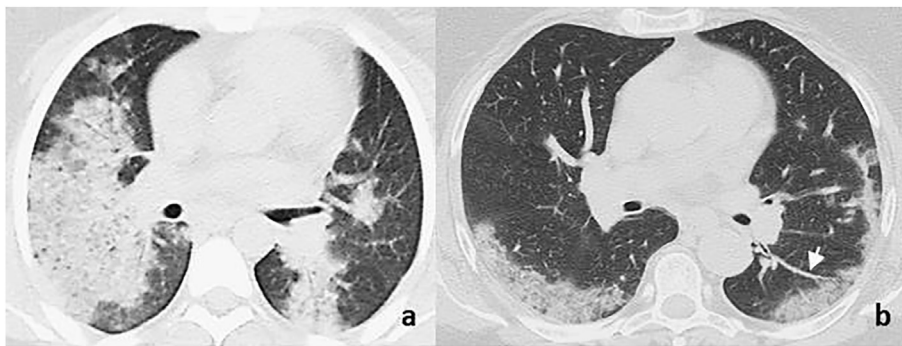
H1N1 vs COVID-19” Vascular enlargement”: HRCT finding. a) A 31-year-old man with fatty liver, alteration of functional liver indices and drug abuse in H1N1 pneumonia. Clinical findings: fever (38.2 °C), jaundice, acute respiratory failure. Axial MDCT scans at lung middle zones show bilateral involvement with rounded multifocal peripheral GGOs confluent in central consolidation and air bronchogram; no vascular enlargement is visible. b) A 60-year-old woman with fever (38.5 °C), non-productive cough and lymphopenia in laboratory-confirmed COVID-19 pneumonia. Axial HRCT shows bilateral lower lobes subpleural GGOs and vascular enlargement on the left base (arrow).
